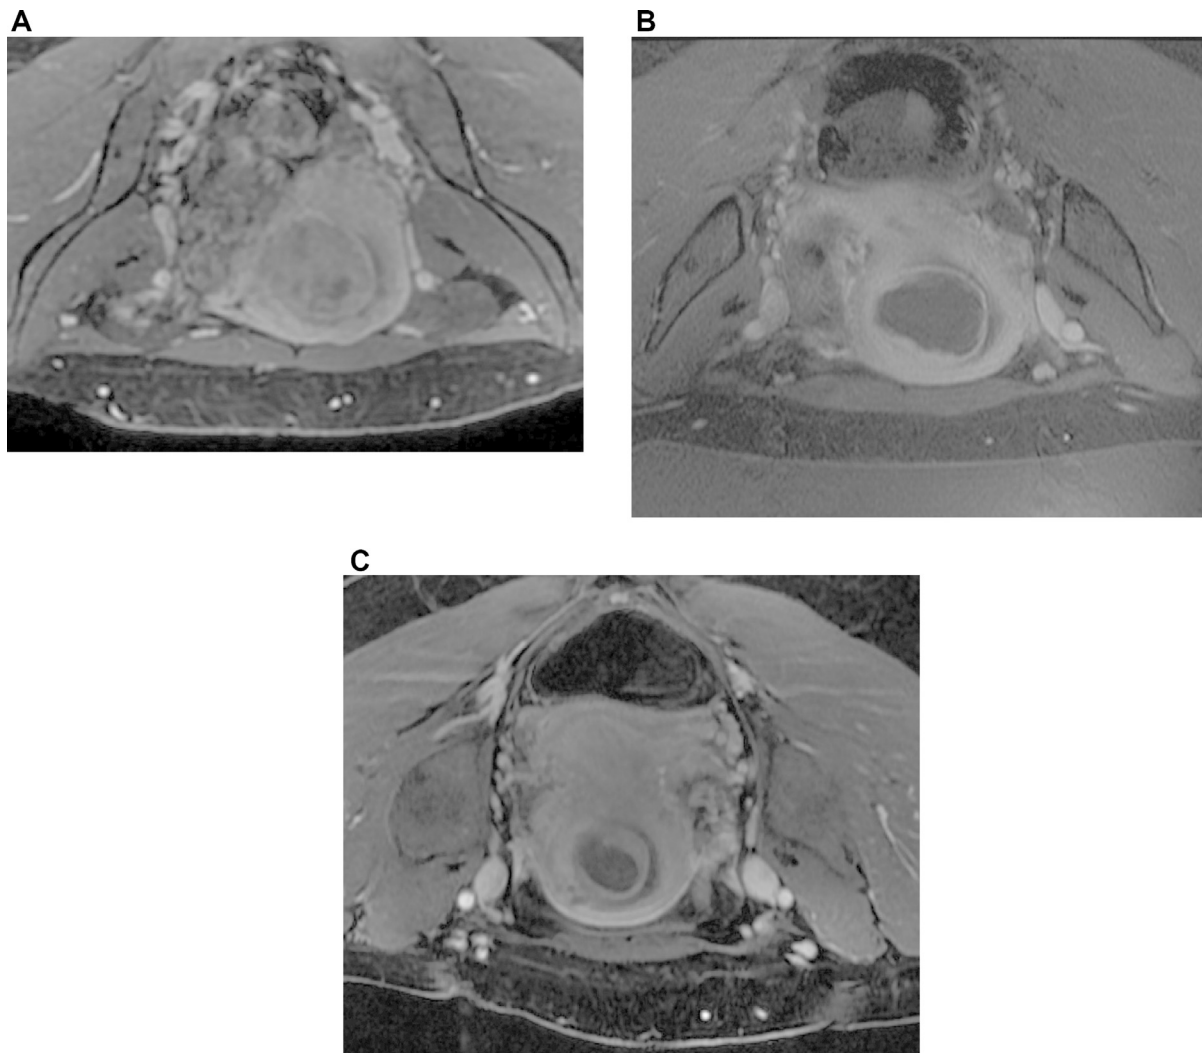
Pre- and post-treatment contrast-enhanced axial Magnetic Resonance images of a patient who underwent MRgFUS treatment for UF. (A) Preprocedural scan demonstrates the presence of an enhancing lesion with diameter of 4cm (B). Postprocedural image shows the necrotic area within the lesion, defined as the NPV (about the 80% of initial volume). (C) Three months after the treatment the volume of the whole lesion decreased, with maximum diameter of 3cm; the nonperfused area is still present within the fibroid.
